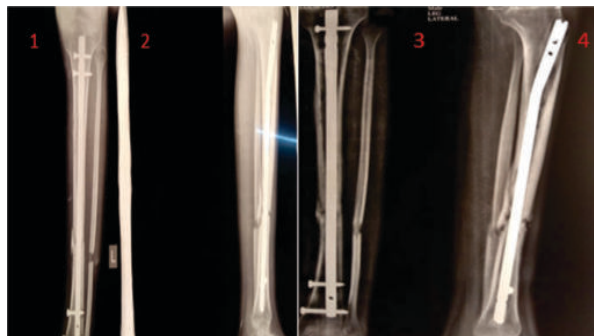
Pretreatment and post treatment radiograph of patient H. AP view (1) and Lateral view (2) showing no signs of union following fixation with IM nail. AP (3) and Lateral (4) view showing still no sign of union at 24 weeks following dynamisation and teriparatide therapy.
